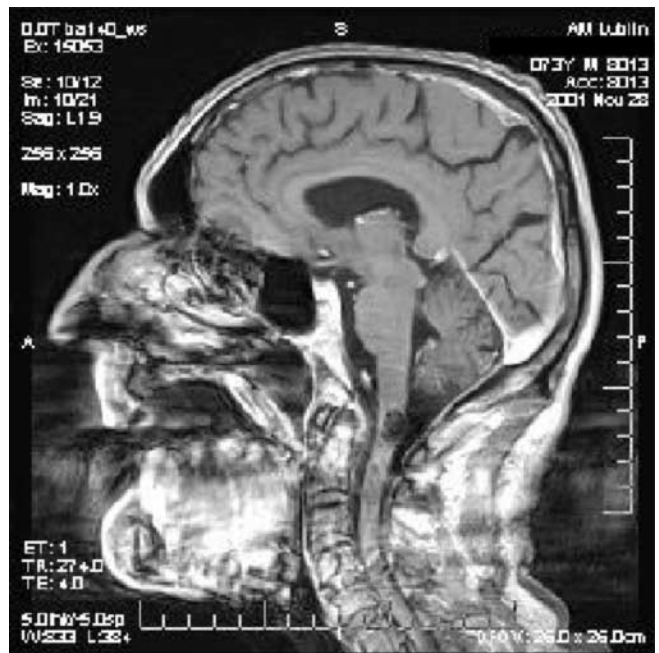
MRI of patient number three
